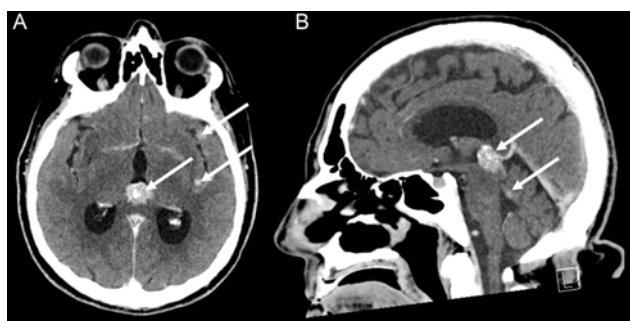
Preoperative computed tomography (CT) demonstrating enhancing lesions within the pineal region, roof of the fourth ventricle and left temporal lobe leptomeninges. Axial (A) and sagittal (B) views.
